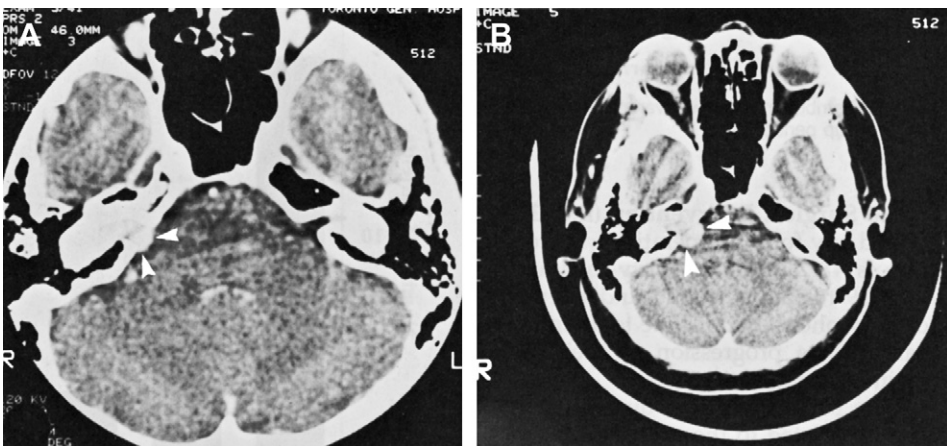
Enhanced axial computed tomography images. Rapidly growing tumor; note threefold increase in size in 9 months. (A) 0.38 cm in August 1985; (B) 1 cm in May 1986.
